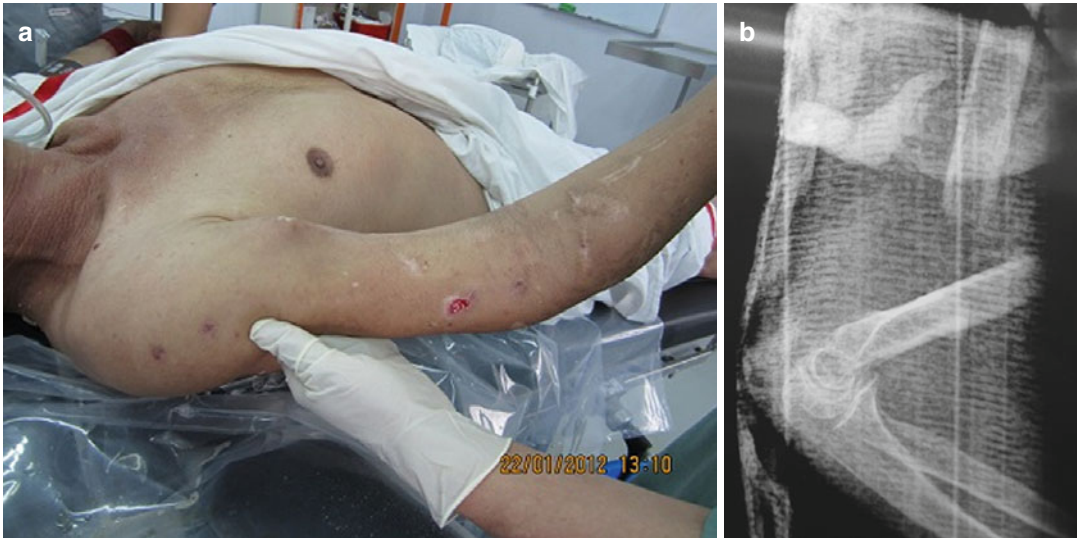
(a) Clinical non union humeral fracture. (b) X-ray humeral non union
